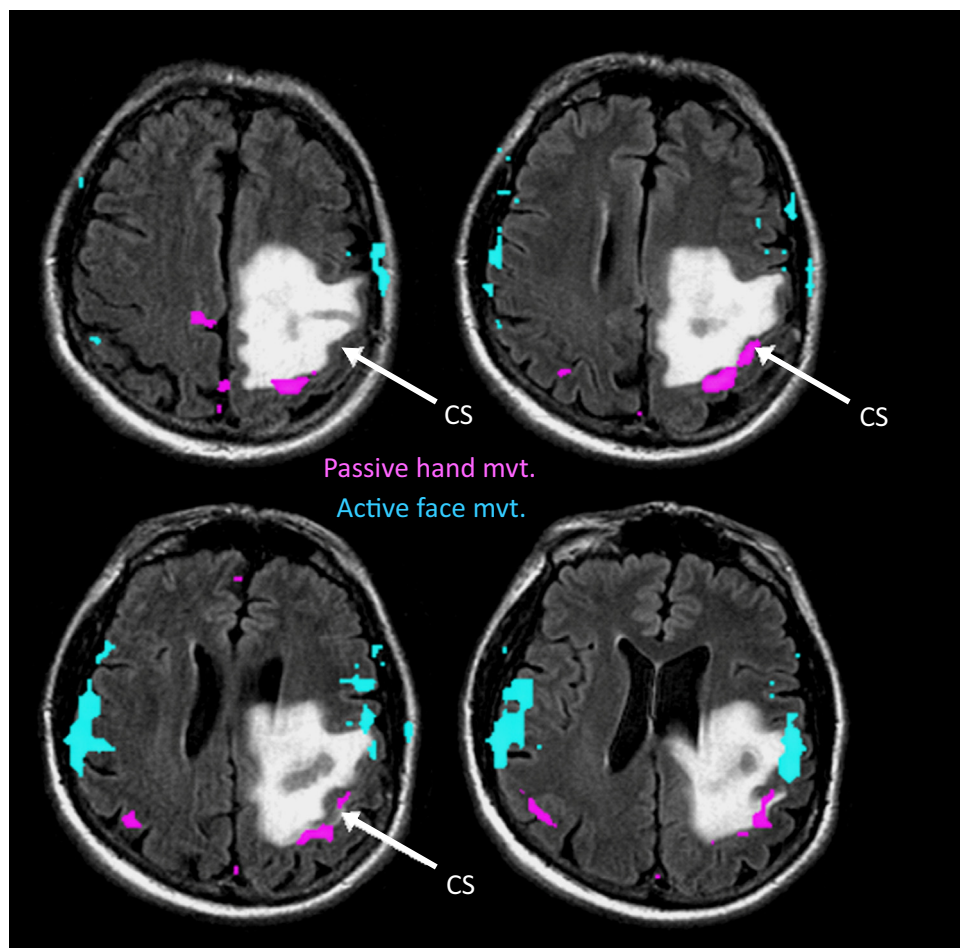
Passive motor mapping can localize MI in patients with lesion-induced paralysis. Axial FLAIR images are shown of a 56-year-old with a brain tumor and edema causing right upper extremity paralysis. Active upper extremity tasks or intraoperative mapping could not be used to help identify the central sulcus or MI cortex. Owing to sensorimotor corticocortical integration, passive hand movements (magenta) localized distal upper extremity MI and SI cortex showing the central sulcus posterior to the lesion. This conclusion was supported by the sensorimotor response to active lower face movement (blue). CS, central sulcus; FLAIR, fluid-attenuated inversion recovery; mvt, movement. (Color version of figure is available online.)
